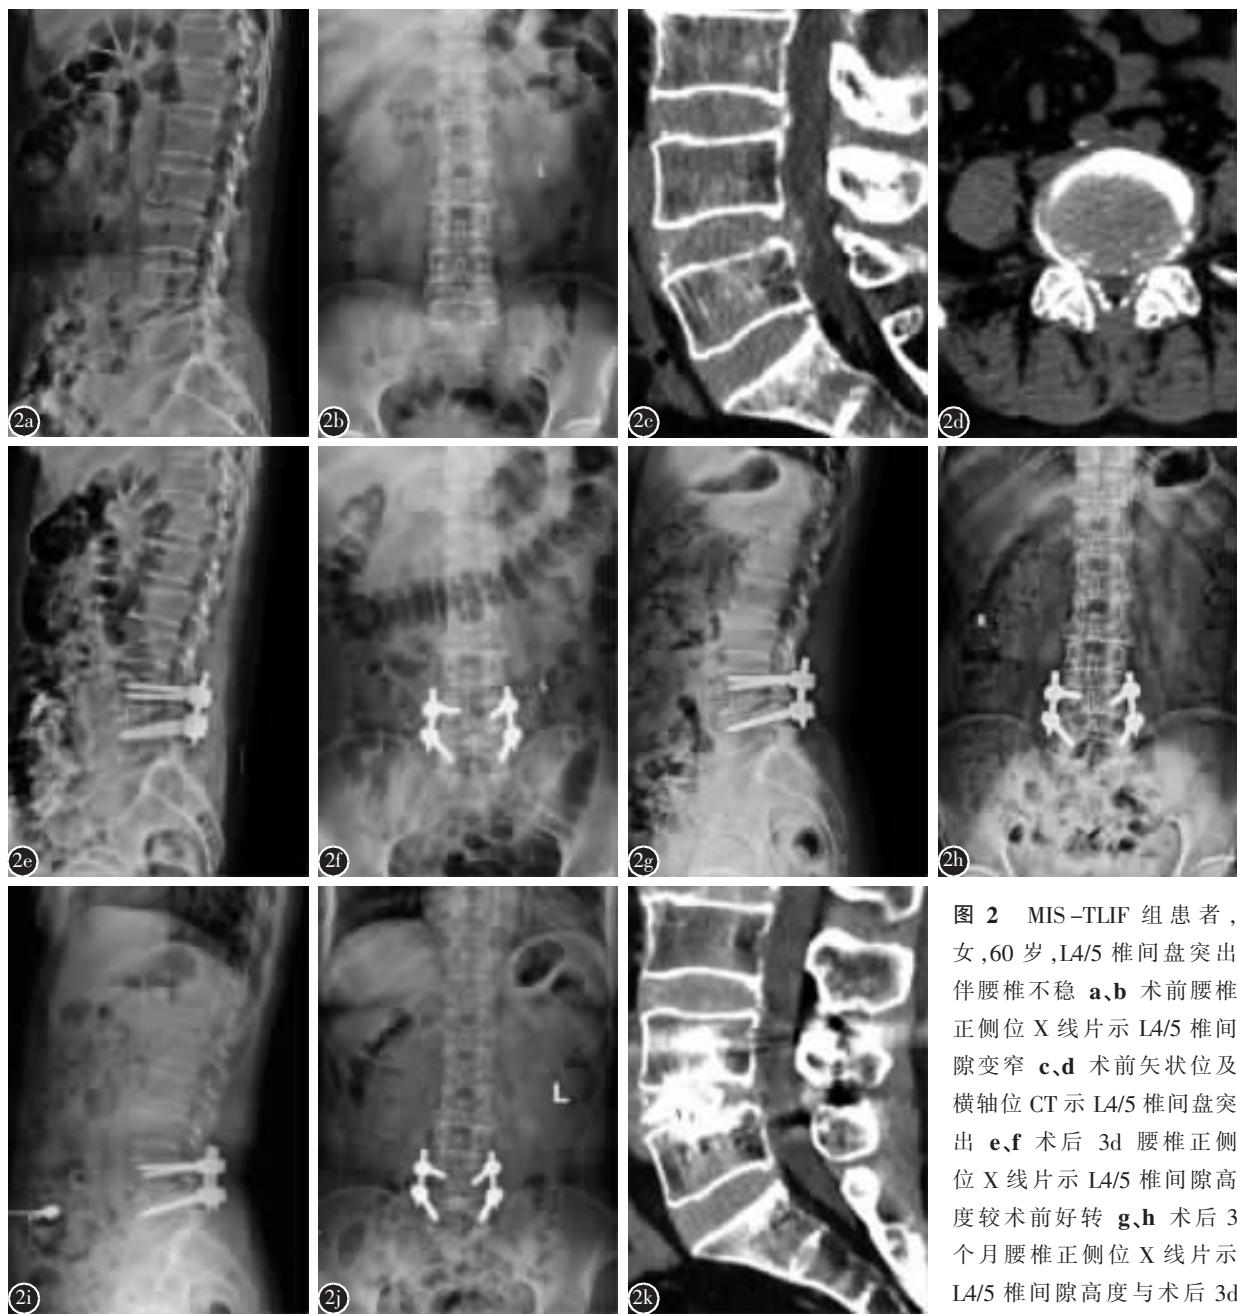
MIS-TLIF 组患者，女，60岁，L4/5 椎间盘突出伴腰椎不稳 a、b 术前腰椎正侧位 X 线片示 L4/5 椎间隙变窄 c、d 术前矢状位及横轴位 CT 示 L4/5 椎间盘突出 e、f 术后 3d 腰椎正侧位 X 线片示 L4/5 椎间隙高度较术前好转 g、h 术后 3 个月腰椎正侧位 X 线片示 L4/5 椎间隙高度与术后 3d 比较无明显变化 i、j 术后 6 个月腰椎正侧位 X 线片示 L4/5 椎间隙高度与术后 3d 比较无明显变化，内固定未见明显松动及移位 k 术后 6 个月矢状位 CT 示 L4/5 椎间达到 I 级骨性融合
